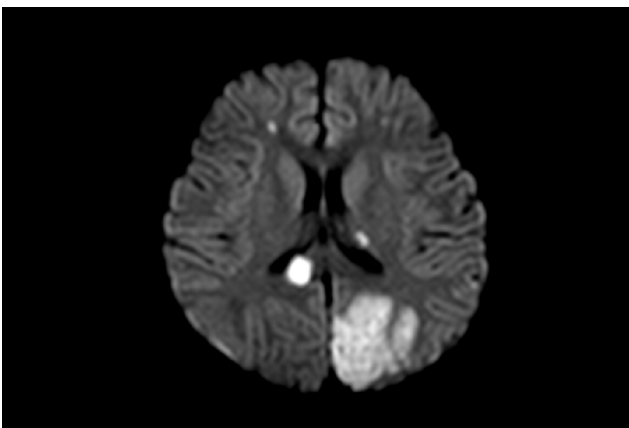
A) Case 1. Brain MRI (FLAIR) showing high signal in parietooccipital lobes and irregular contrast enhancement. B) Case 1. Brain MRI (T2) showing high signal noted in parietooccipital lobes and irregular contrast enhancement.
